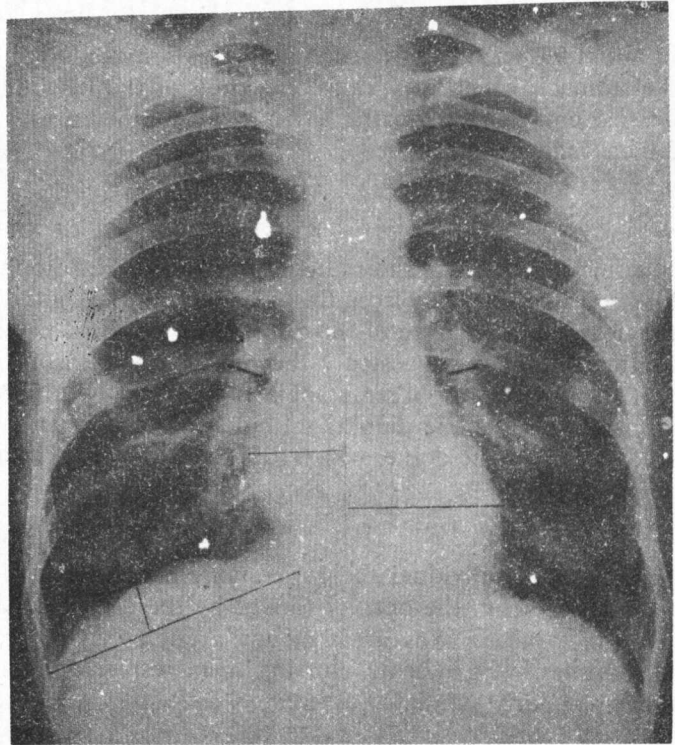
Lines marked on radiograph to show a method of measuring the transverse diameter of the heart and the basal arteries. Method of assessing diaphragm curve also shown. Dots to right and left hilum points.
